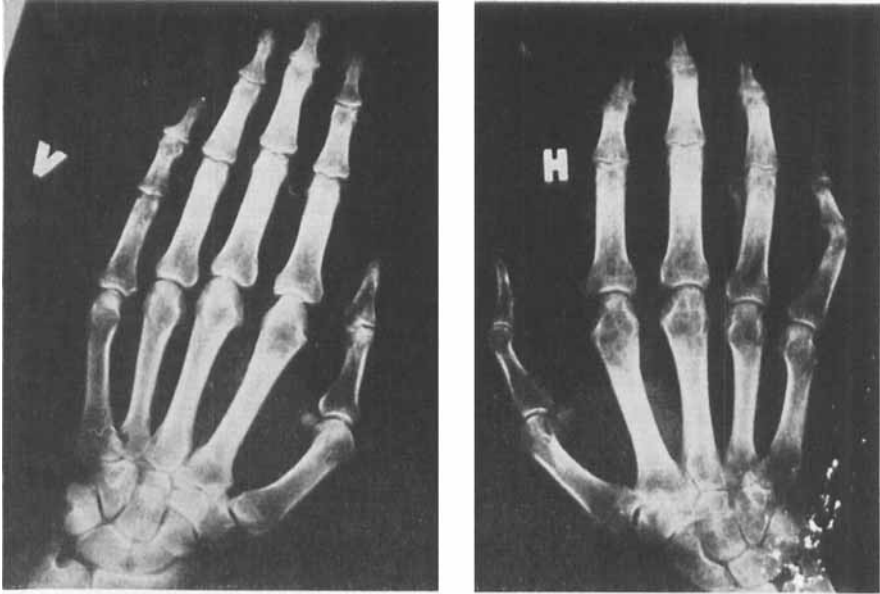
X-ray of the hand skeleton of patient 2. Note the osteopenia of the right injured hand.
